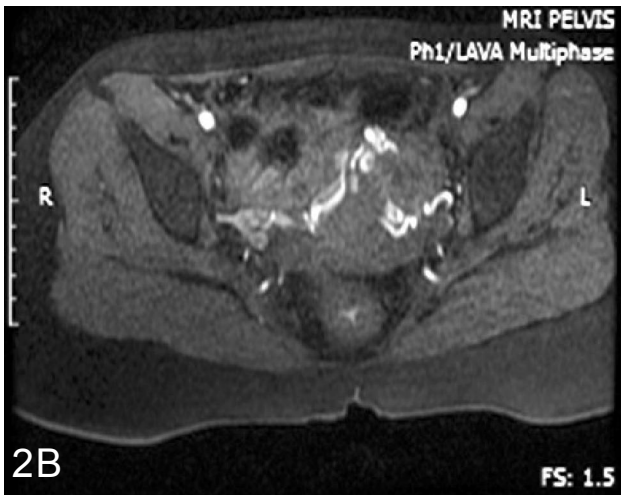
Magnetic resonance images showing the vessels as signal void, black arrow (A), hyperintense tortuous vessels, black arrow (B) and volume rendered processed image of the AVM, white arrow (C).
